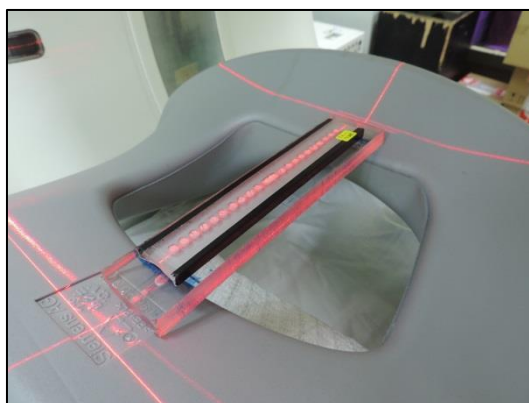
The TLD-100 case at the isocenter of CT scanner.
